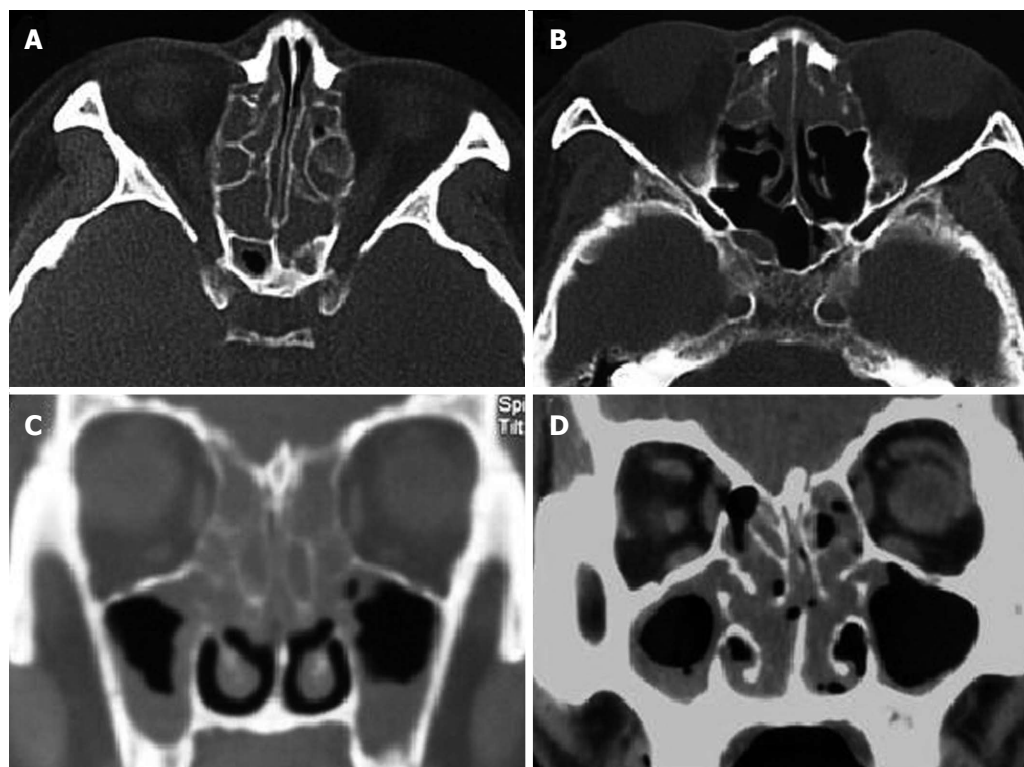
Computed tomography findings. Axial and frontal sections in the subtypes of eosinophilic chronic rhinosinusitis with nasal polyps (ECRSwNP) (A and C) and non-eosinophilic chronic rhinosinusitis with nasal polyps (NECRSwNP) (B and D). Predominant diseases in bilateral anterior and posterior ethmoid sinuses are showed in ECRSwNP, while predominant diseases in anterior ethmoid sinuses in NECRSwNP.
